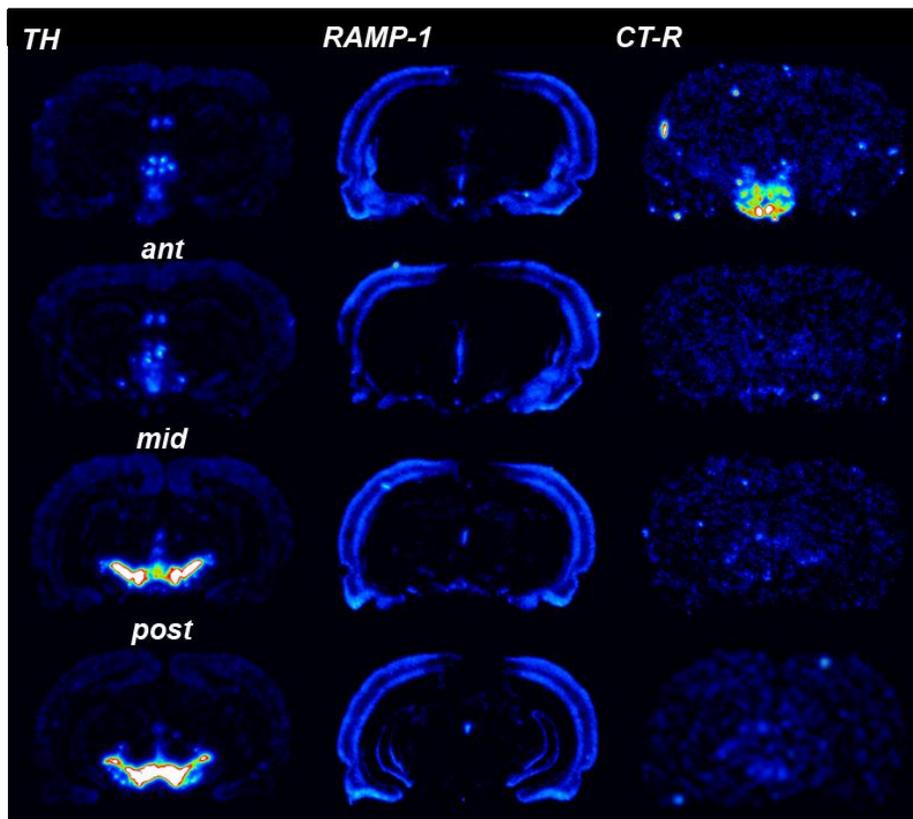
Pseudocolor images showing hybridization of probes for tyrosine hydroxylase (TH), RAMP-3, and CT-R in the ventral tegmental area (VTA) and neighboring regions. Warmer colors indicate greater labeling intensity; white shows highest intensity. ant = Anterior, mid = Middle, post = Posterior.
